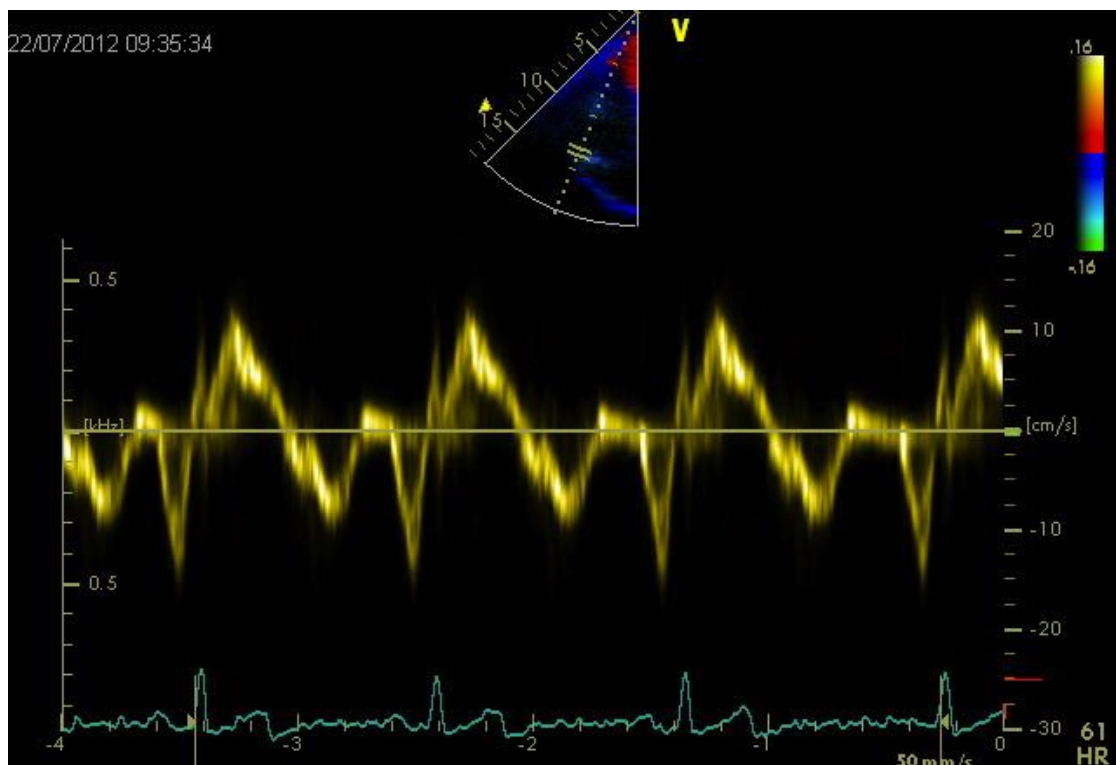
Pulsed Wave (PW) Tissue Doppler Imaging (TDI) signals derived from the basal lateral wall of the RV displaying instantaneous longitudinal velocity (cm/s) of focused myocardial movement throughout the cardiac cycle. See section 1.15.3
